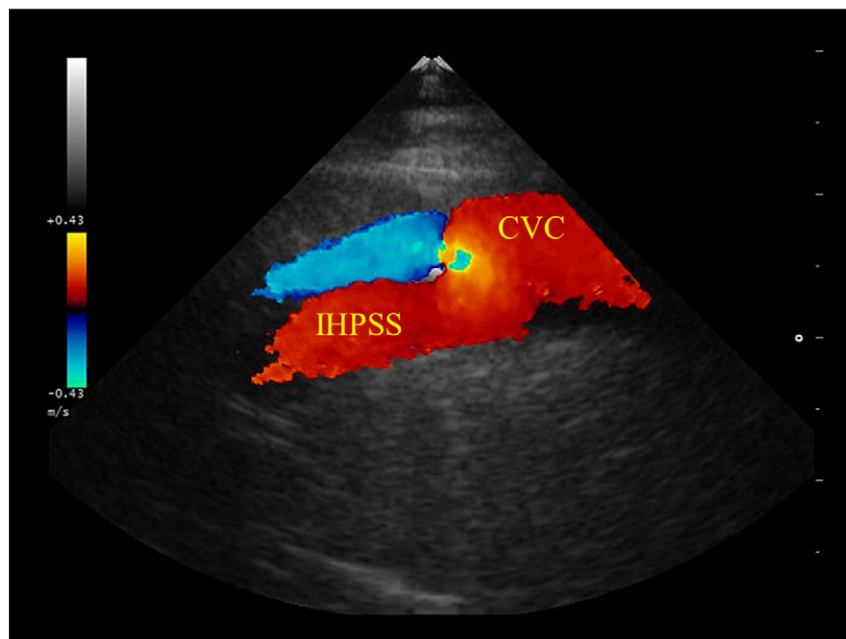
Transesophageal ultrasonography colour Doppler image: a longitudinal view of the IHPSS's exit. The pre-procedural qualitative analysis of the blood flow from the left tubular type of IHPSS into the caudal vena cava. CVC: caudal vena cava; IHPSS: intrahepatic portosystemic shunt.
